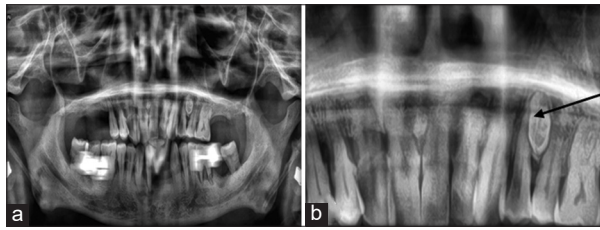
(a) Orthopantomogram (OPG); (b) OPG showing odontome (case 3)
